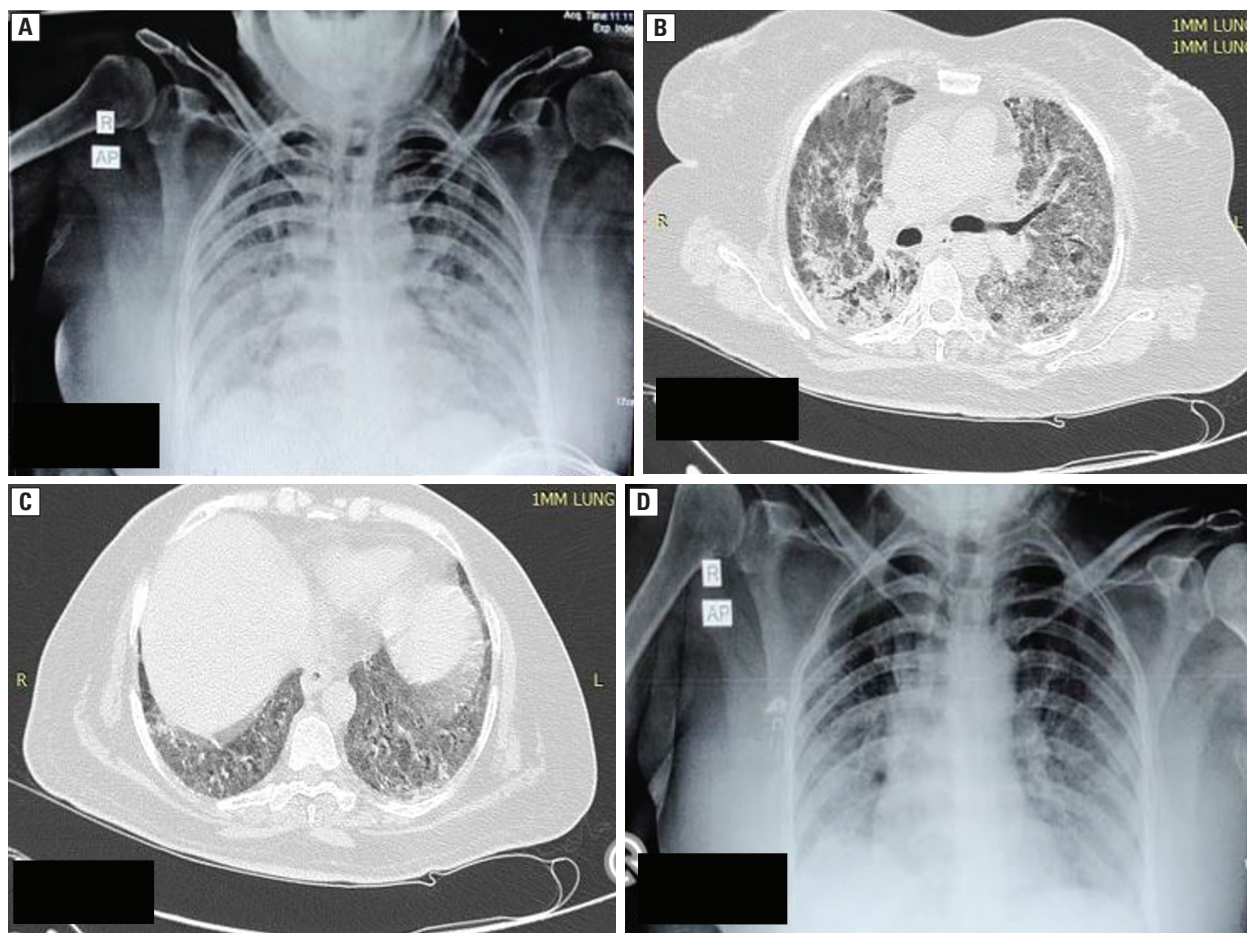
Chest skiagram showing bilateral airspace opacities in mid and lower zones; B, C. High resolution computed tomogram of chest showing pulmonary fibrosis in bilateral lower lobes; D. Chest skiagram showing improvement after 3 weeks of antifibrotics therapy
